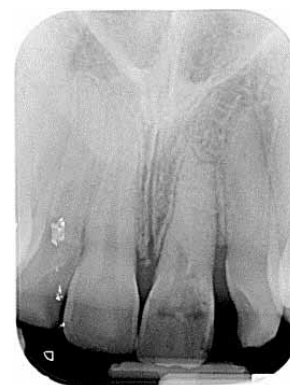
Radiograph taken 1 year after surgery. There is evidence of sclerosis of the root canal of the UL1.
